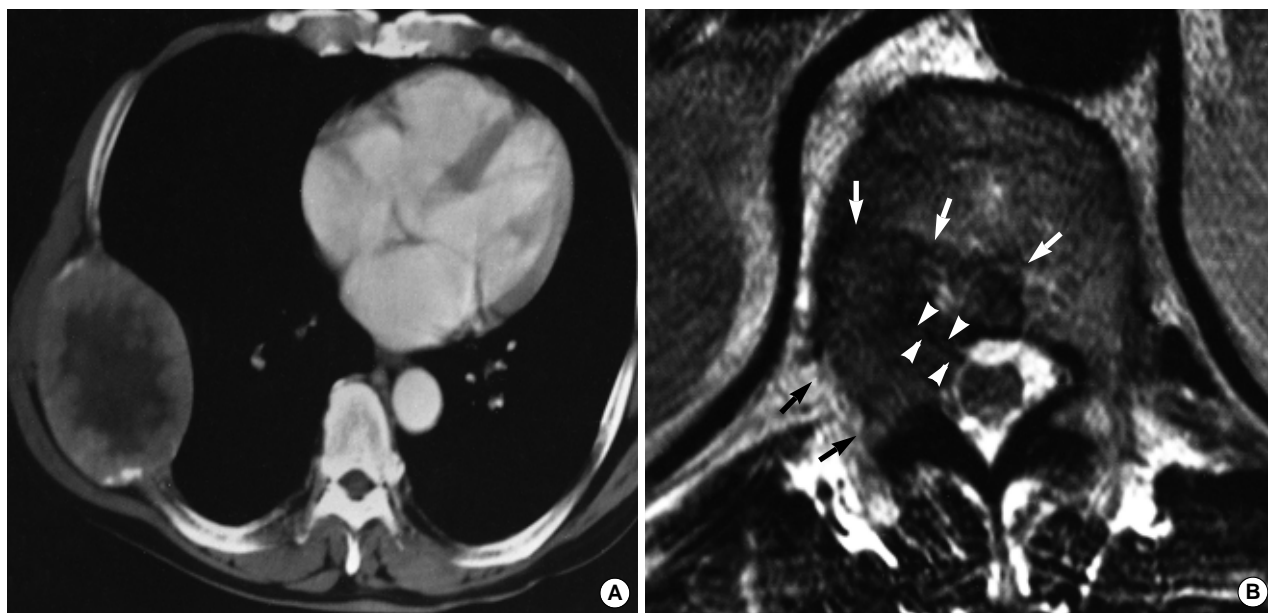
(A) Enhanced chest CT scan reveals huge extrapleural mass with osteolytic change of right seventh rib. The mass has central irregular area of low-density that represents necrosis. High-density foci at peripheral margin of the mass are not enhancing vessels but small bony fragment. Enlarged tumor vessels are not seen on CT scan. (B) Two years later, axial T2-weighted image through T12 vertebra shows intermediate signal intensity mass involving the right posterior vertebral body and the pedicle with epidural mass (arrows). There are tubular signal void structures within the mass that may represent feeding arteries from the spinal artery (arrowheads).
